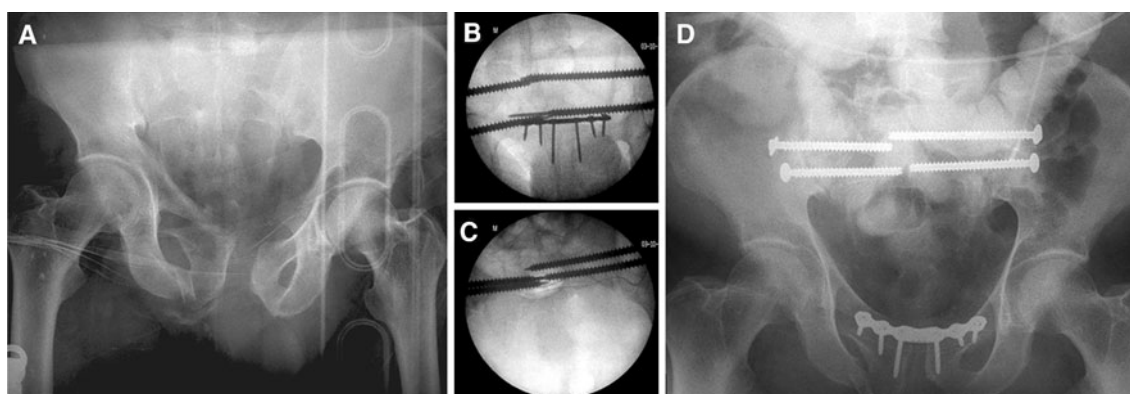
Radiographs of patient no. 26 (male, 54 years). The patient was admitted to our ER with pelvic ring injury type APC-III with LC III-component of the contralateral right side a and blunt abdominal trauma secondary to traumatic entrapment on a construction site. Percutaneous
